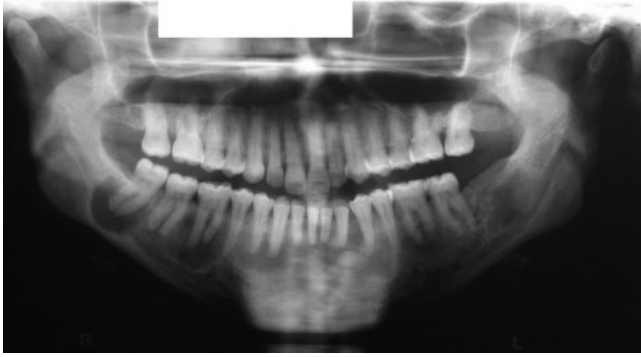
Two years post-debond orthopantomograph
